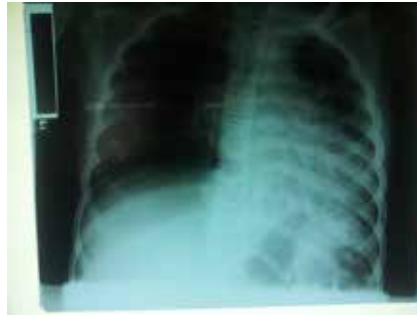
Post-operation X-ray after second bronchoscopy. The removal of the foreign body resulted in better left lung tissue aeration and reduced right lung hyperinflation.
